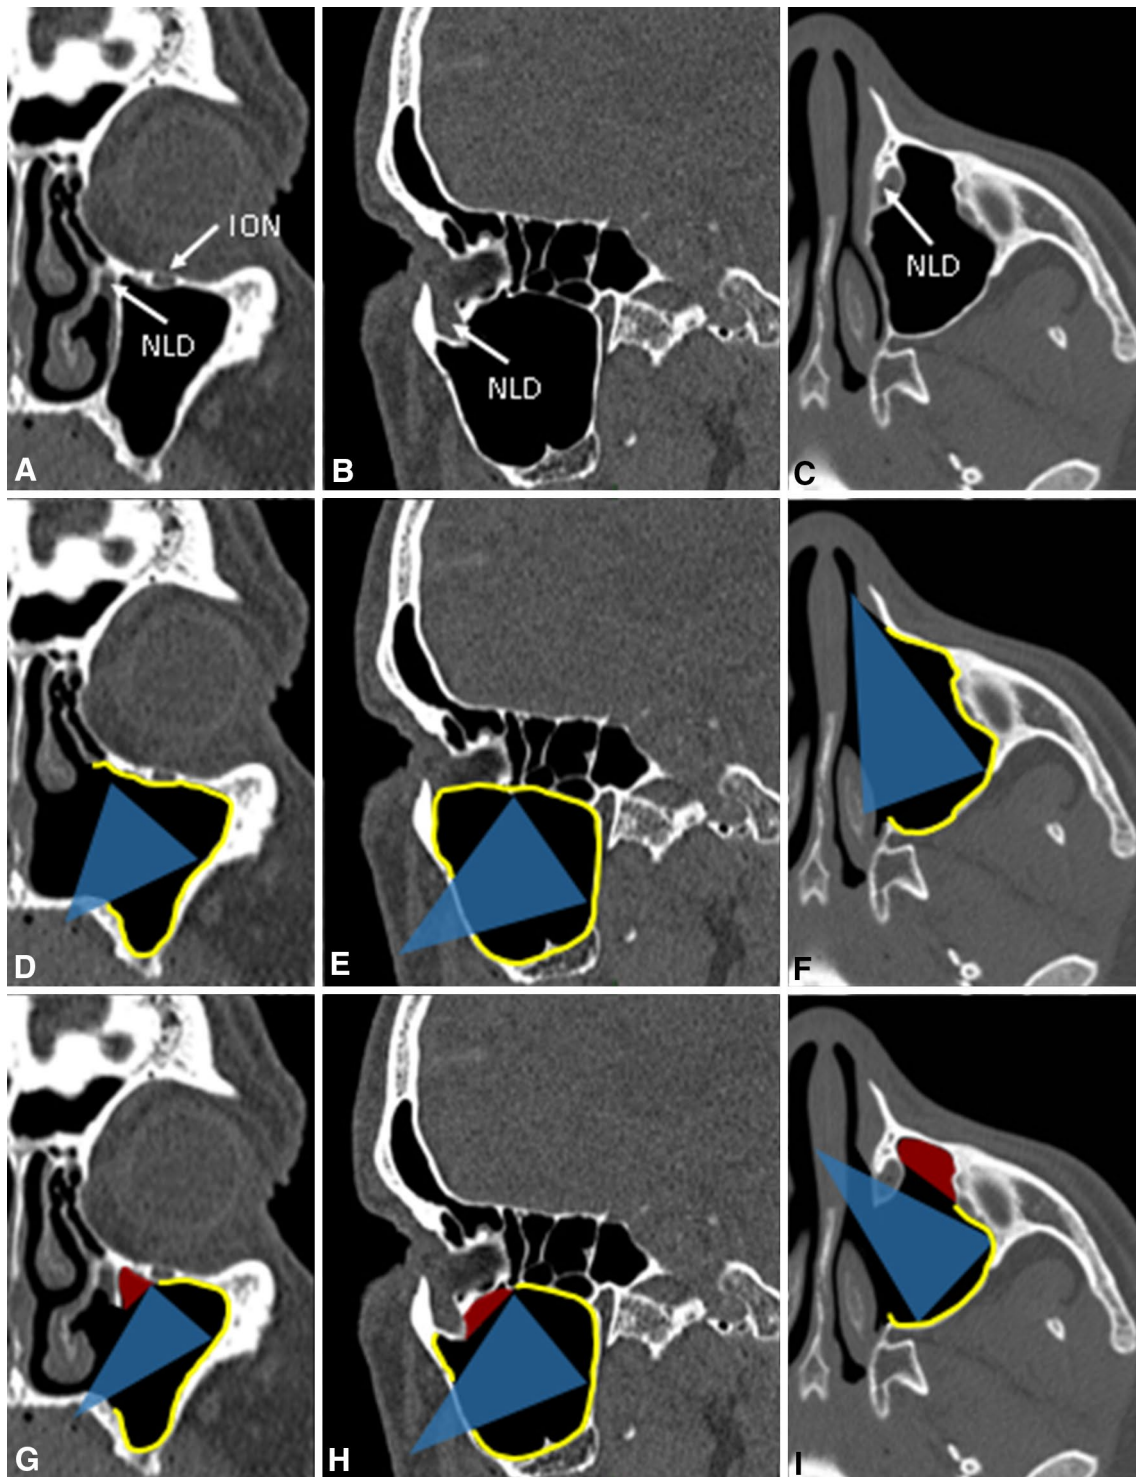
Coronal, sagittal and axial CT scans showing the concepts of the resections and the surgical area that can be explored inside the maxillary sinus. a–c *NLD* nasolacrimal duct, *ION* infraorbital nerve. d–f An “extended” EMM is shown: in this approach, almost all
